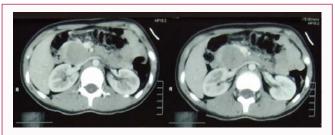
Axial view of abdominal CT scan (post contrast) with a mass in pancreatic head, measuring 33 mm \times 31 mm \times 41 mm in size compressed right kidney vein and inferior vena cava.
